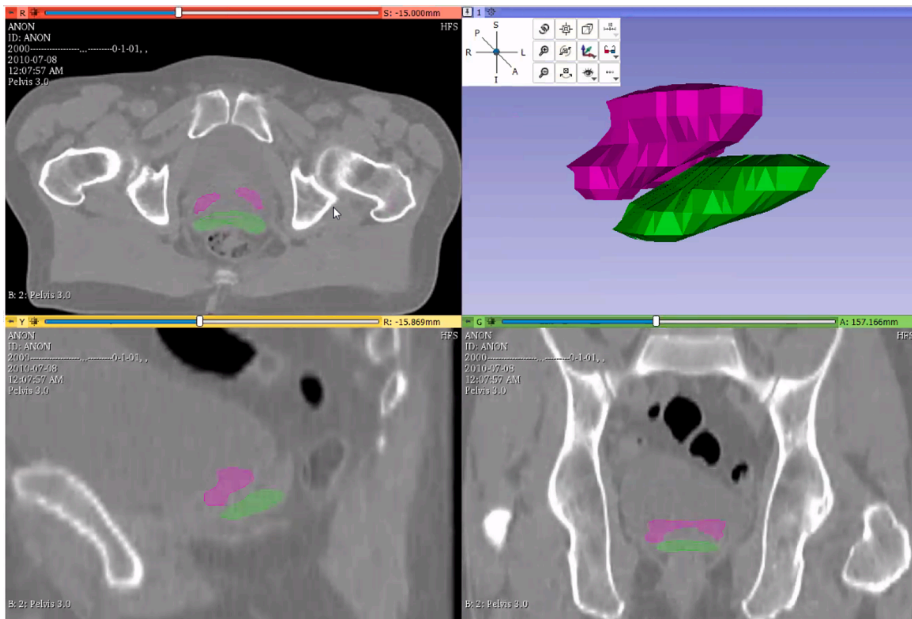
Example of similar seminal vesical volume with minimal overlap. 3D Slicer Image of SV location in dMRI (pink) and pCT (green) scans on transverse, sagittal and coronal medical imaging planes, and 3D generated image. Abbreviations: SV = seminal vesicle, dMRI = diagnostic magnetic resonance imaging, pCT = planning CT. (For interpretation of the references to colour in this figure legend, the reader is referred to the web version of this article.)
